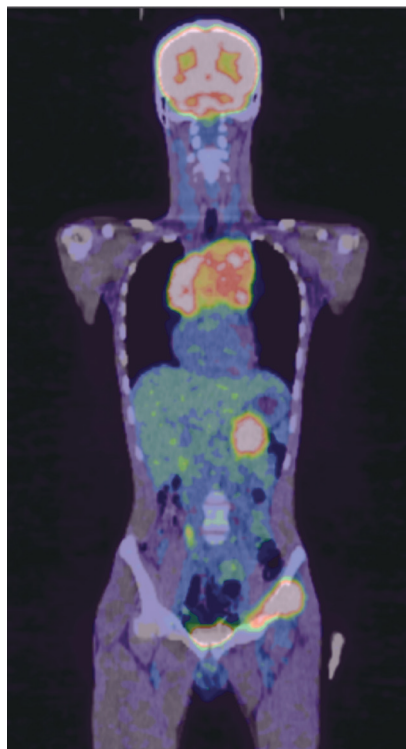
FDG/PET demonstrated multiple masses in the anterior mediastinum, right upper pole of the kidney, hilum of the spleen, and left coxal bone.
